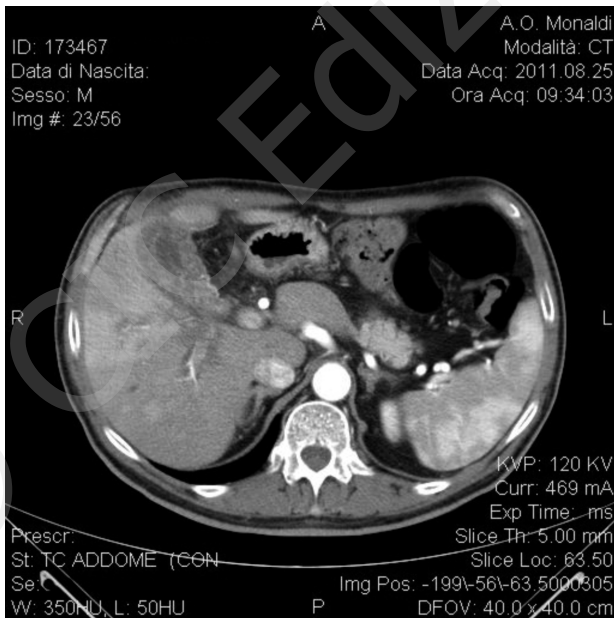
CT scan showing inhomogeneous parenchymal enhancement at the early arterial phase.
